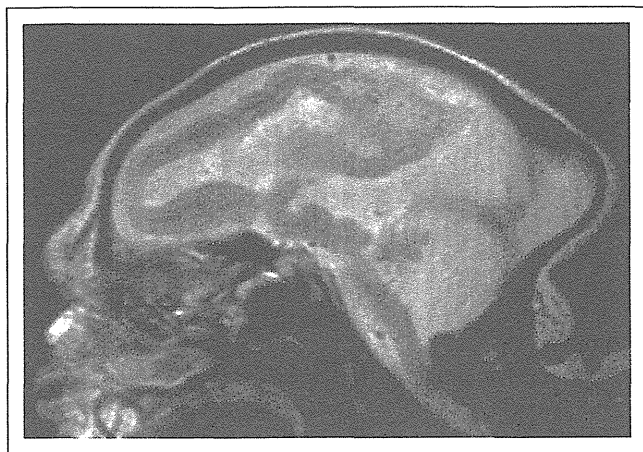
Sagittal T2-weighted magnetic resonance imaging (MRI) shows a thin cortex and white matter with an undetectable border. Prominent hypoplasia of the cerebellum and brainstem is visible.
